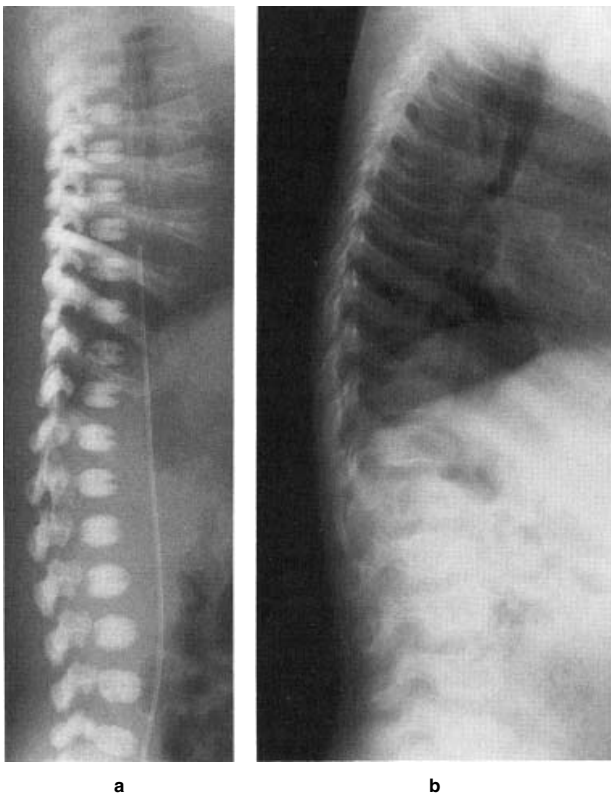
Radiographs of the spine in spondyloepiphyseal dysplasia congenita. a: Lateral projection showing ovoid vertebral bodies in a newborn. b: Lateral projection showing flattening of vertebral bodies in a 10-year-old child. The vertebral end plates are irregular.
